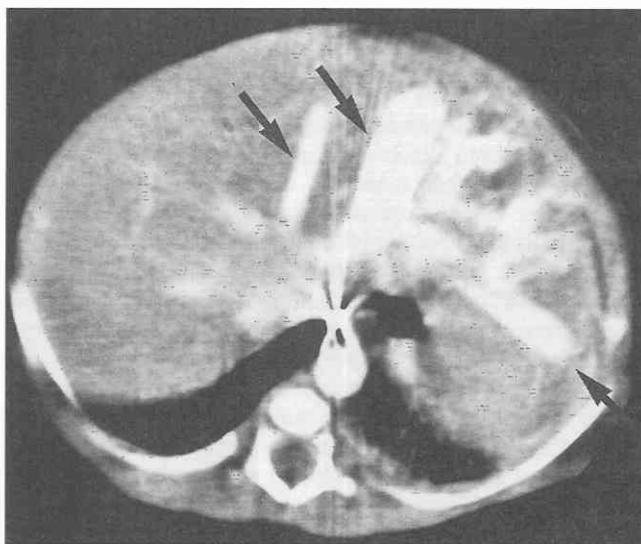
Hemangioendothelioma. CT of the liver shows the enlarged draining hepatic veins (arrows) in this infant with hemangioendothelioma.
